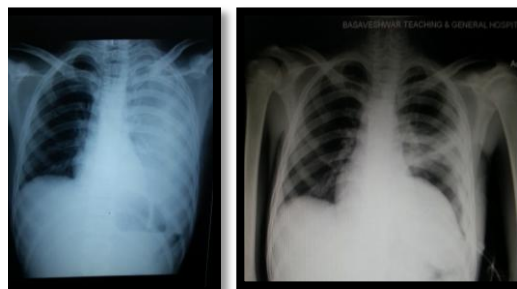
Fig III Chest X-ray, before and after ICD placement
